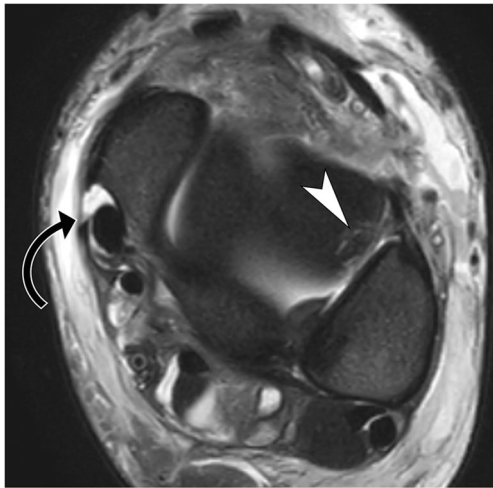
Multiligamentous injury in a 15-year-old boy sustained while playing soccer. In addition to tears of the ATFL, CFL, deep, and superficial deltoid (not shown), an axial fat-suppressed T2-weighted MR image of the ankle depicts tear of the flexor retinaculum (curved arrow) with subluxation of the posterior tibialis tendon, as well as osteochondral fracture of the lateral talar dome (arrowhead)
